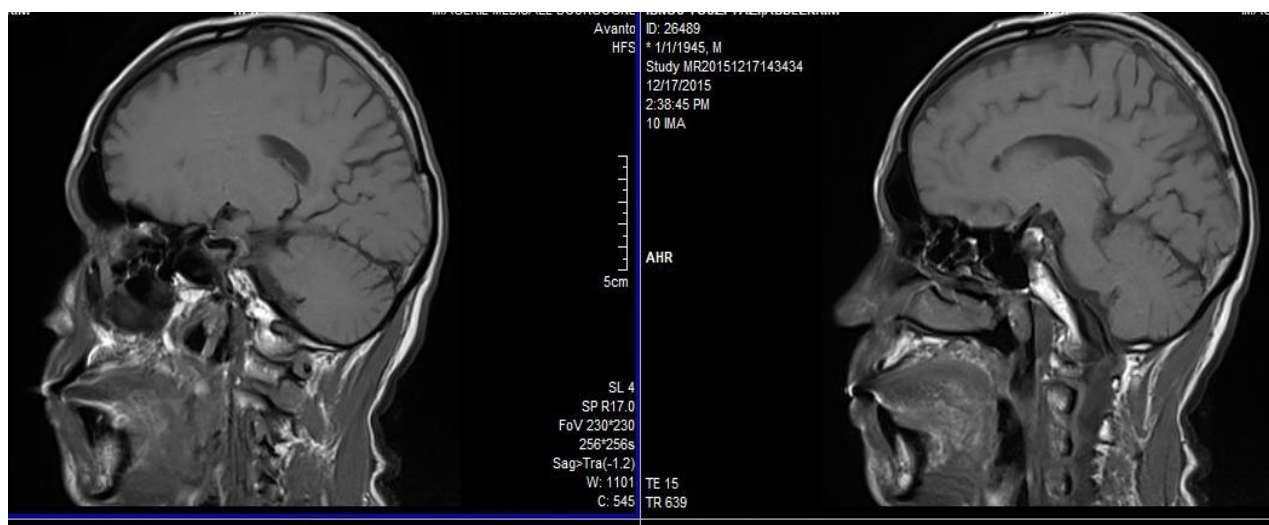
Cerebral magnetic resonance imaging sagittal cut showing a left hippocampal atrophy
